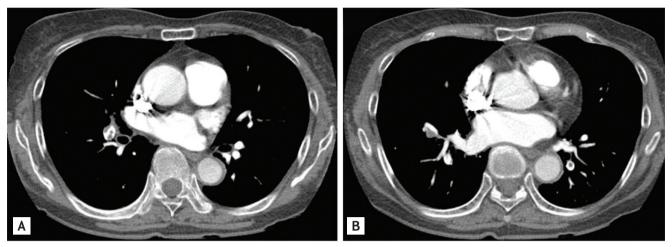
(A, B) Axial images taken via computed tomography. Multiple embolisms are evident in both pulmonary arteries.
